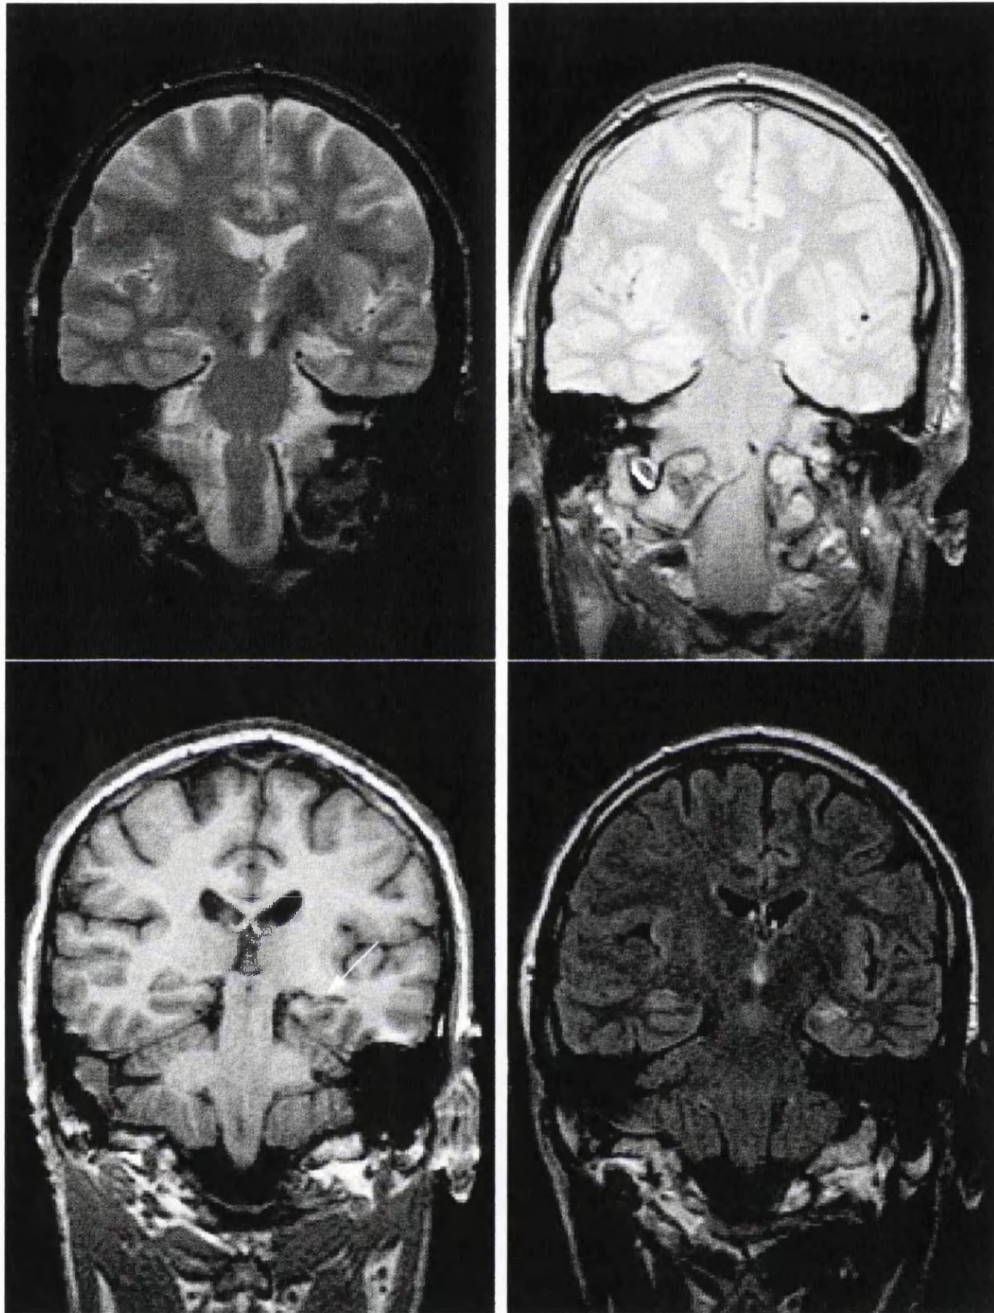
Left HIPPOCAMPAL SCLEROSIS. Coronal images of the hippocampal body. Spin echo T2-weighted image (top left), proton density weighted image (top right), T1-weighted image (bottom left) and fast FLAIR image (bottom right). The left hippocampus (arrow) is smaller than the right and returns a high signal on T2-weighted images. This is most conspicuous on fast FLAIR since CSF signal has been suppressed.
